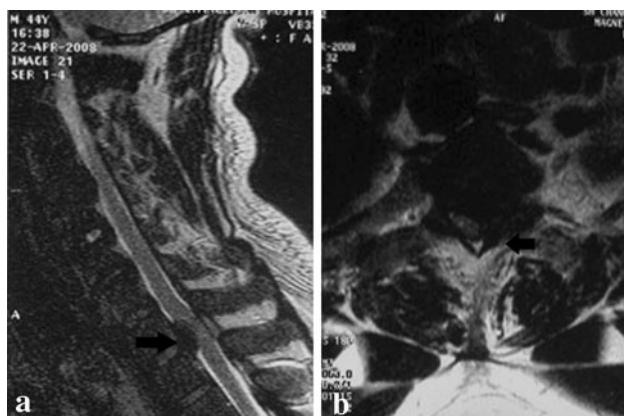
MRI showed OPLL and left OLF with severe spinal cord compression and intramedullary high intensity on T2-weighted images at T1-2. a OPLL (black arrow), b OLF (black arrow)
